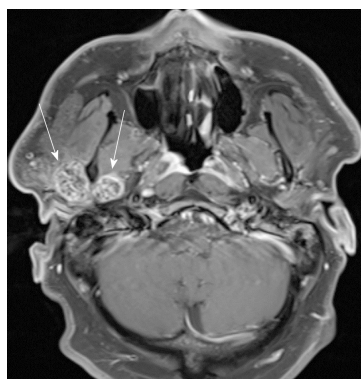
Axial cut of magnetic resonance imaging T1 weighted post-contrast image depicting the bilobed mass within the temporomandibular joint space on either side of the mandibular condyle (arrows) with associated joint capsule distention. On magnetic resonance imaging STIR sequence images (not pictured), significant joint effusion is noted.
